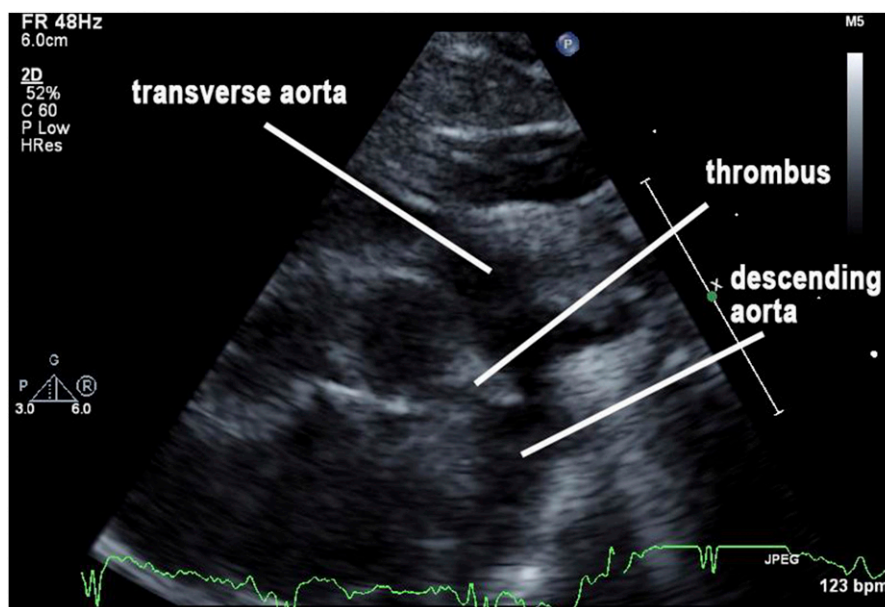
Echocardiographic images captured along the suprasternal notch view demonstrate the aortic arch. Here the patent ductus arteriosus thrombus is seen protruding into the descending aorta.
